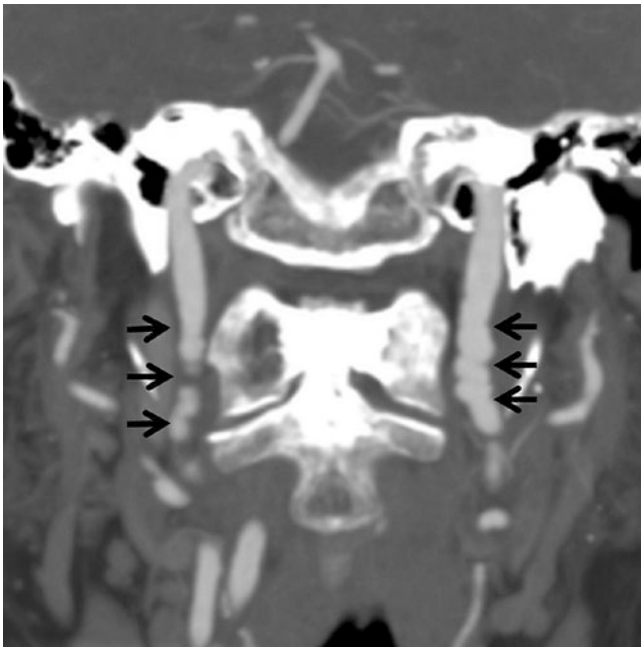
Fibromuscular dysplasia mimicking grade I injury. Coronal CTA demonstrates contour irregularity of bilateral cervical ICAs with “string of beads” type of appearance, in a patient after motor vehicle crash. CTA of the abdomen shows similar appearance of renal arteries. This is most consistent with fibromuscular dysplasia. Follow-up CTA in 6 months does not show interval change
